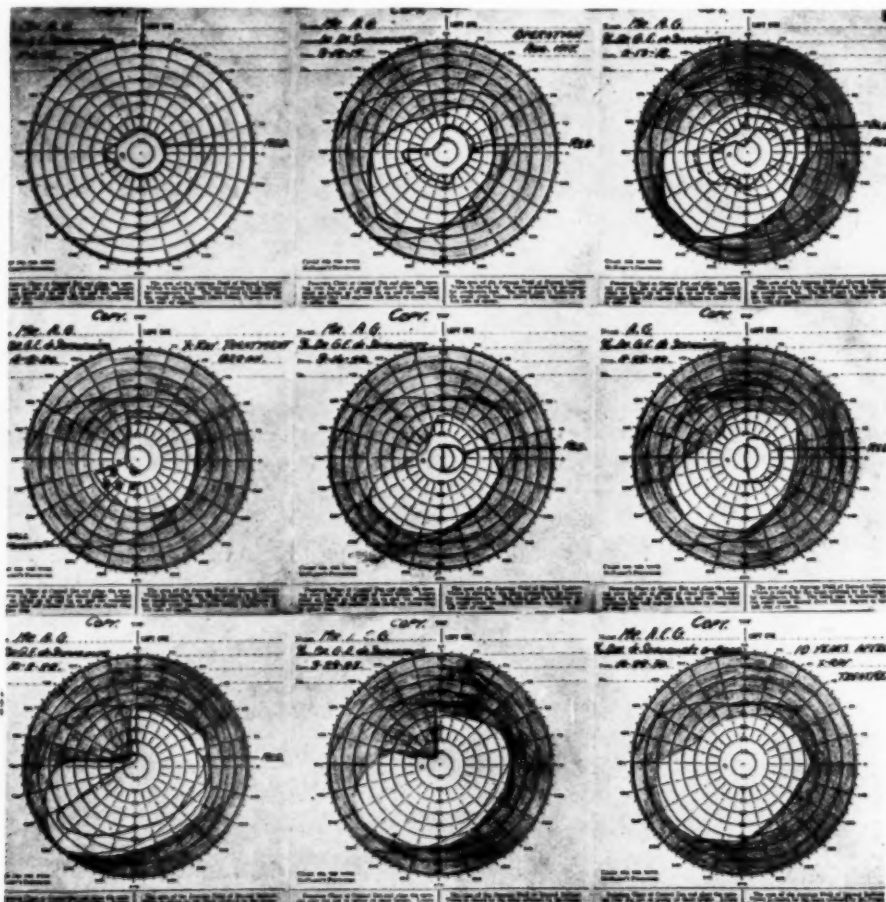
(Pfahler and Spackman). Case 1 shows a series of records of the field of vision as recorded by Prof. G. E. deSchweinitz and his associate, Dr. B. F. Baer, Jr., from time to time, from May 3, 1916 to October 20, 1930. In the first field of vision made May 3, 1916, the contracted red fields are shown. The second field made September 18, 1917, was made one month after the operation by Prof. Chas. Frazier, and shows a definite improvement in the red field. This was followed by further improvement shown in the field recorded February 13, 1918, but by April 8, 1920, there was a definite contraction of the total field of vision to about one-third, and at this time, x-ray treatment was begun. The following fields of vision made September 16, 1920, November 22, 1920, October 2, 1922, March 29, 1923, and October 20, 1930, show a progressive increase in the fields until it is practically normal; it has remained approximately normal during eight years.
